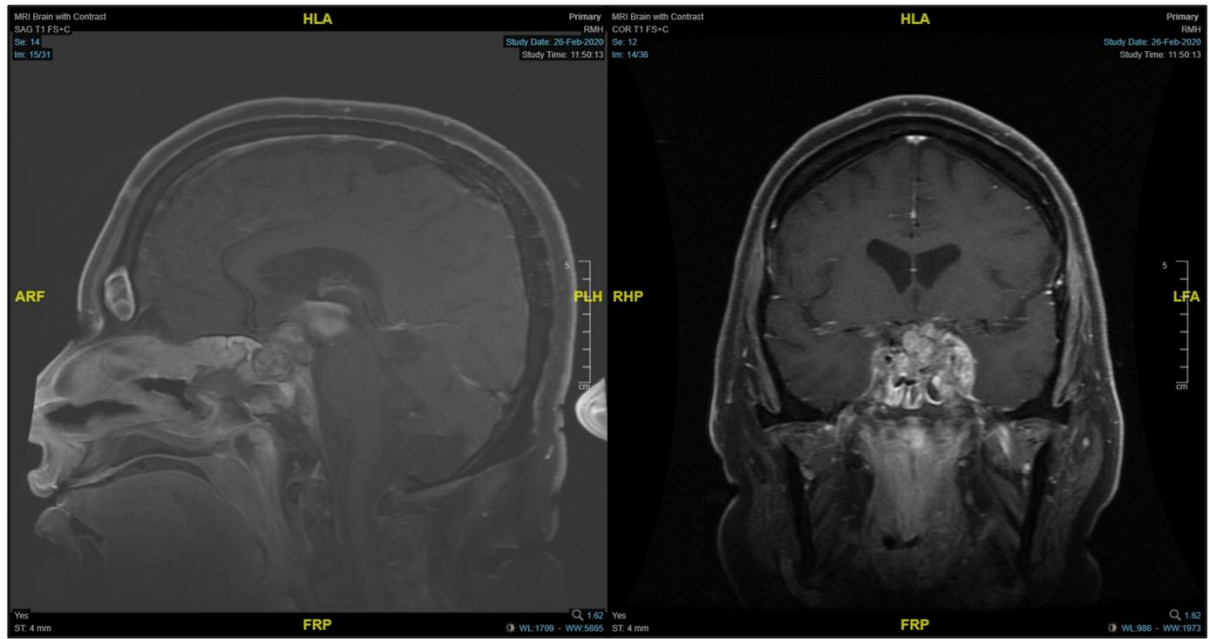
MRI brain with contrast showing Slight interval progression of lesion size with heterogeneous texture/enhancement and ill-defined margins. And development of subacute intraventricular hemorrhage predominantly involving third ventricle.
